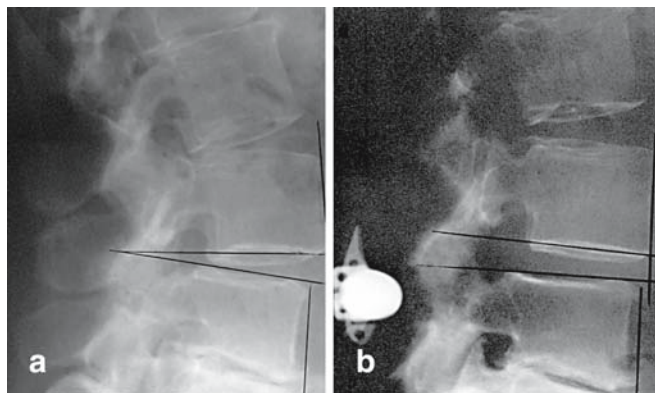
a Preoperative standing upright lateral radiographic view of a degenerative spine. b Postoperative standing upright view with the X-Stop placed between the spinous processes. Note the enlarging of the foramen
